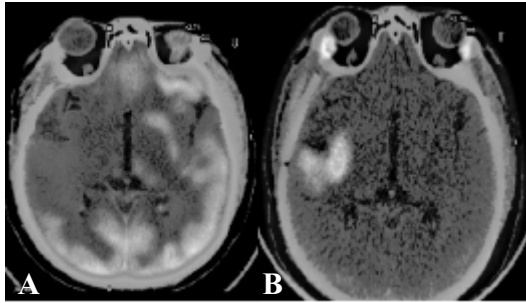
A post-operative case of grade II glioma. FDG PET/CT image (A) shows no area of increased uptake at the operative site s/o negative study. However, 11C-methionine scan (B) clearly shows recurrence in the right temporal region (arrow).
